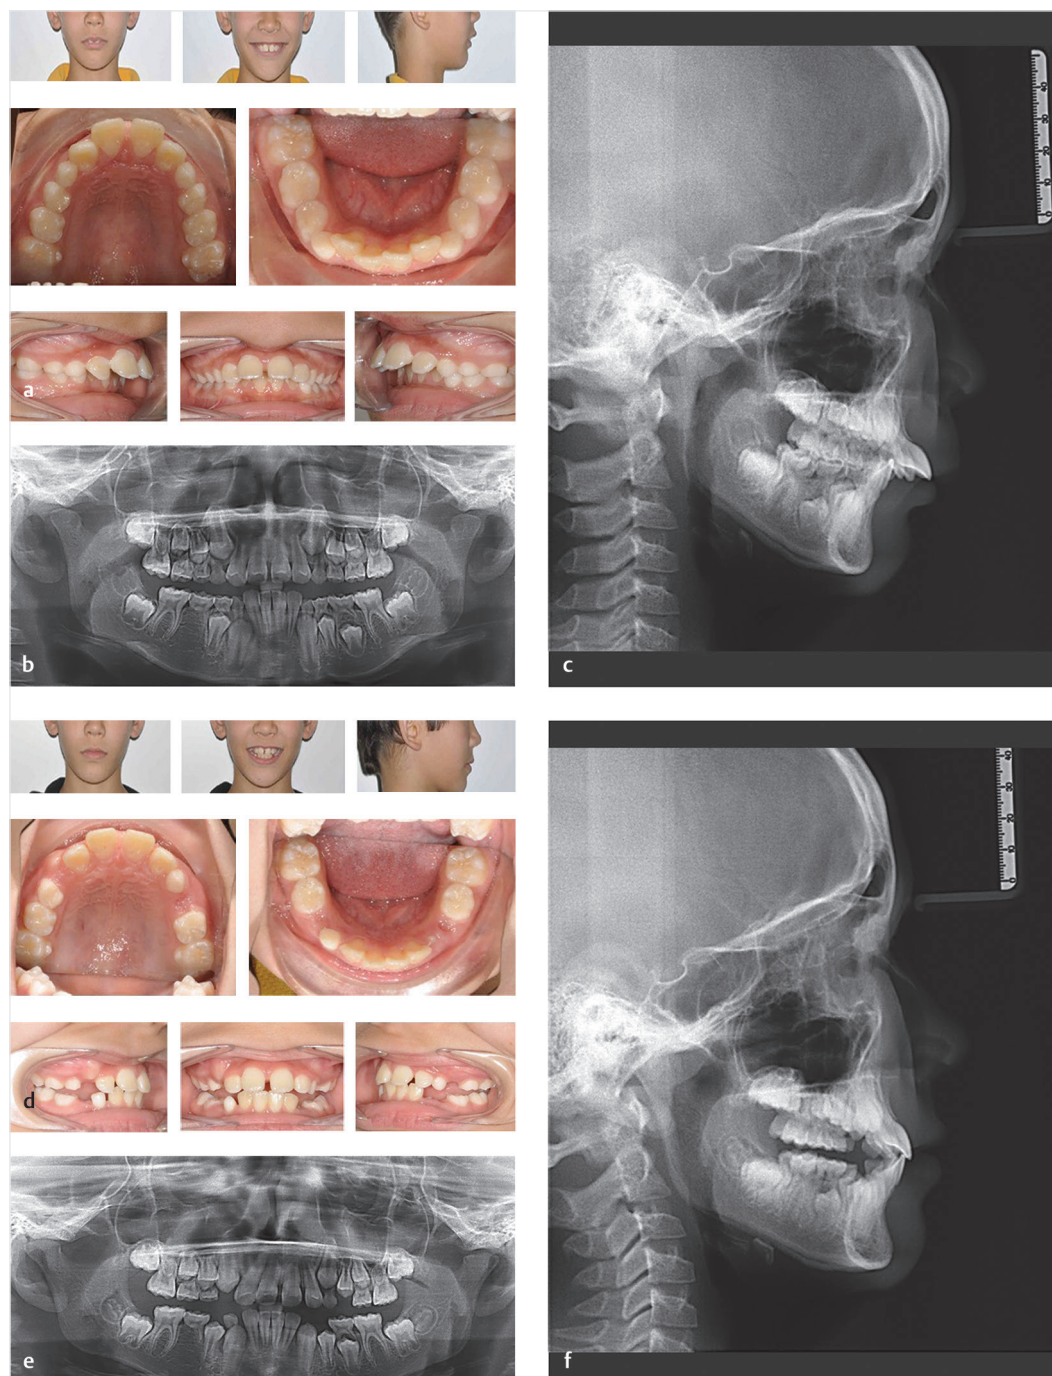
(a) Early interceptive treatment of a 10-year 1-month old child with a removable functional appliance. (b) Pretreatment panoramic radiograph. (c) Pretreatment lateral cephalometric radiograph. (d) Interceptive treatment completed in 10 months. (e) Post stage I treatment panoramic radiograph. (f) Post stage I treatment lateral cephalometric radiograph.
